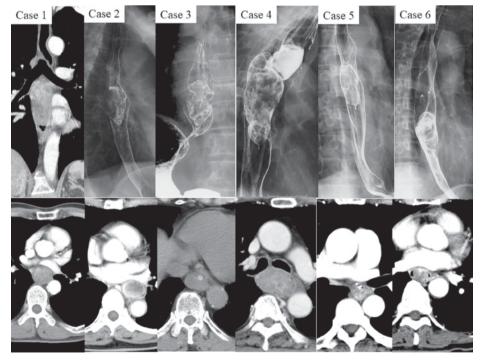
Radiography of the upper gastrointestinal tract and chest computed tomography indicating an intraluminal polypoid lesion in all 6 cases. The mean tumor size was 6.5 cm (major axis, 2.5-10.5 cm).
